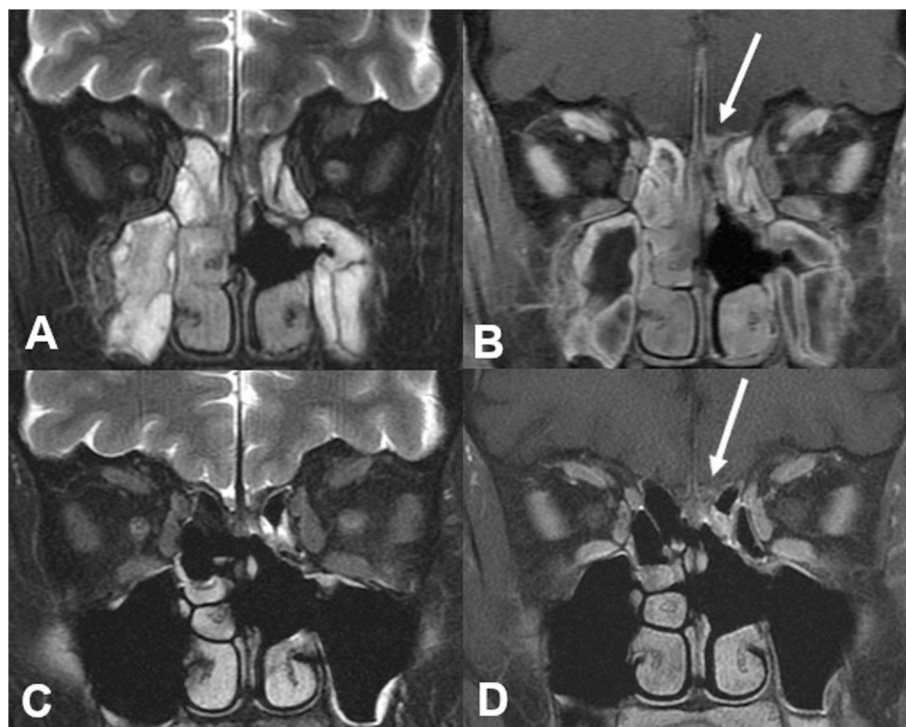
MRI from follow-up at one month (A,B) and five months (C,D). Images show progressive resolution of T2 hypointense soft tissue thickening (A, C). Post-contrast images (B, D) show resolution of dural enhancement (arrows).
